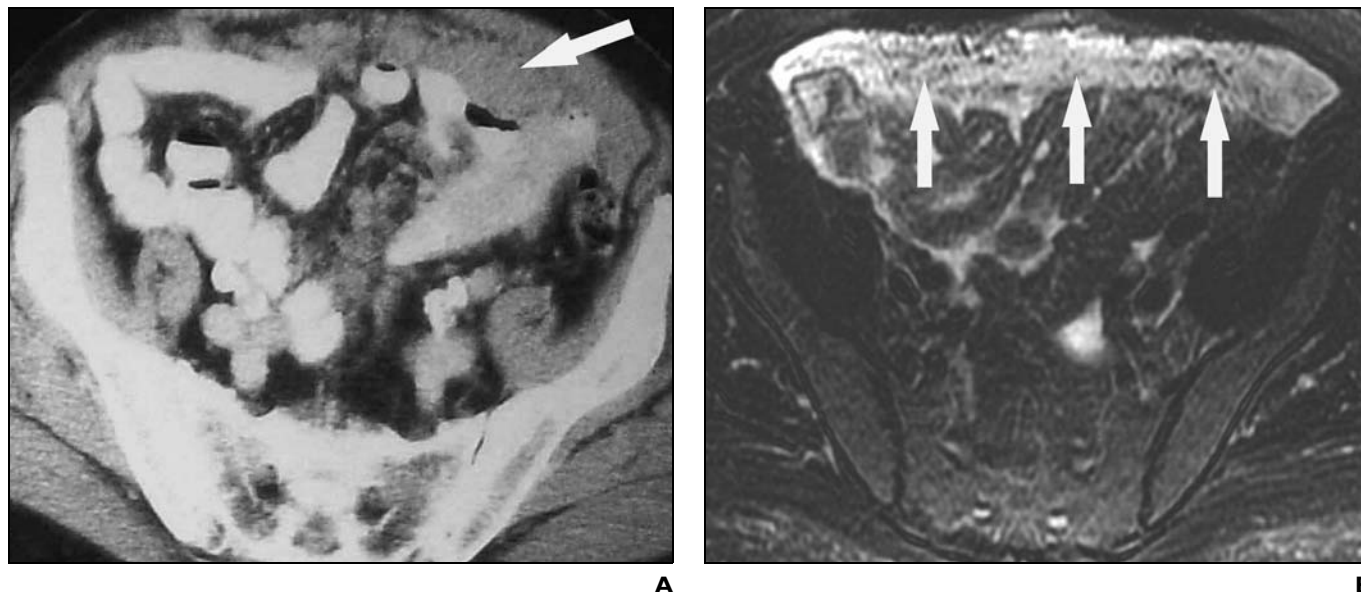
76-year-old man with small-bowel gastrointestinal stromal tumor. A and B, Axial contrast-enhanced CT scan (A) and axial T2-weighted fat-suppressed fast spin-echo MRI (B) of pelvis show omental caking (arrows).
